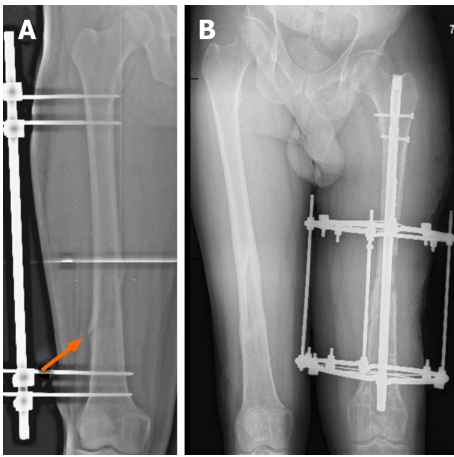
An X-Ray of both femurs after occurrence of pathological fractures. A: Pathological fracture occurred in the right femur, despite previous external AO fixation. Orange arrow indicates the location of the fracture B: An X-Ray of both thighs. Right femur completely healed (after 6 mo of treatment). On the left: External fixation with Ilizarov's apparatus, intramedullary osteosynthesis with silver-plated intramedullary nail. An X-Ray shows a significant shortening of the left limb.
